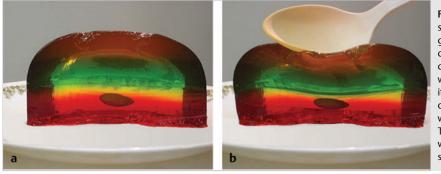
A simplified model of the principle of strain elastography. (a) Consider an almond in gelatin. (b) If we apply a stress, such as compressing the gelatin with a spoon, the gelatin changes shape because it is soft (more strain), while the almond does not change shape because it is stiff (less strain). The ultrasound strain system compares the frame-to-frame changes of tissue when the tissue is compressed and released. Tissues that deform the most are considered soft, while those that deform the least are considered stiff.
